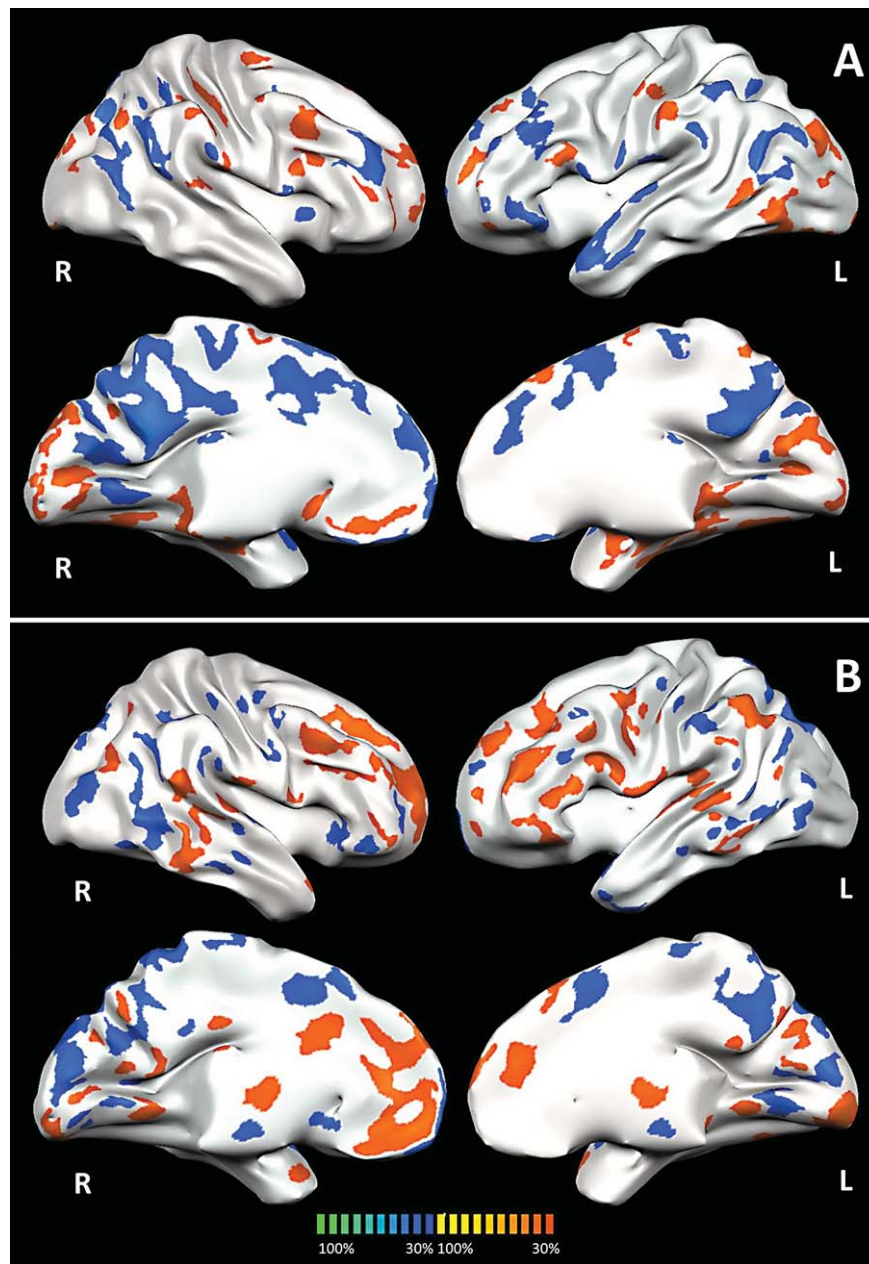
Probabilistic maps with the areas with the highest cumulative predictive weights for all the measures. A) FTD-GRN+. B) aGRN+. Blue to green are areas with “reduced” activity that predict for the pathological sample, red to yellow are areas with “increased” activity that predict for the pathological sample. These images shows the spatial overlap of the predictive patterns relative to the different measures here employed. Results are superimposed on 3D T1 MRI template. FTD-GRN+, frontotemporal dementia carrying *Granulin* mutation; aGRN+, asymptomatic carriers of *Granulin* mutation.
